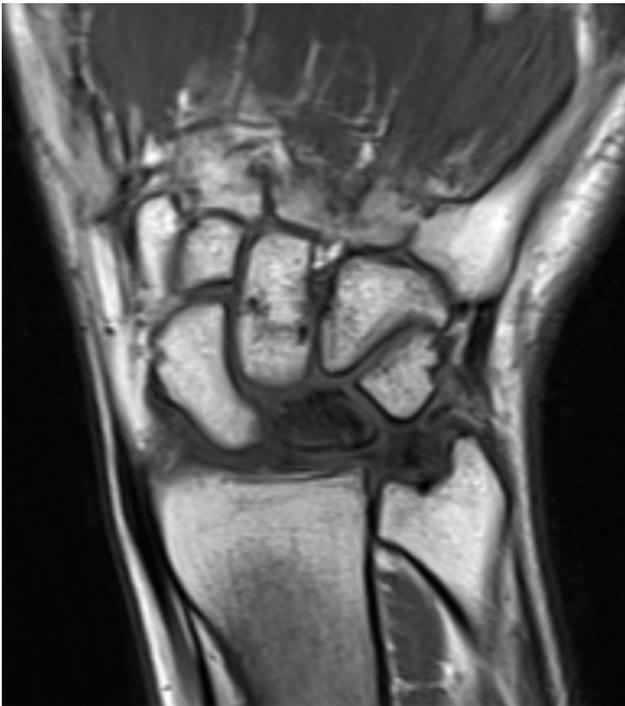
MRI image showing Kienböck's disease in a patient.
